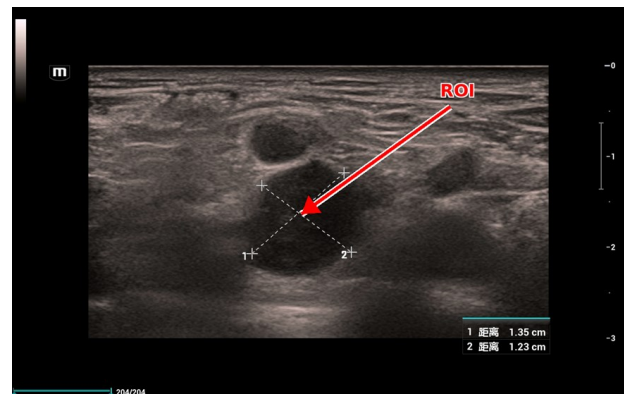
Representative grayscale ultrasound image of a suspicious lymph node with caliper measurement. The arrow indicates the target region of interest (ROI) selected for ultrasound-guided core-needle biopsy (CNB).
